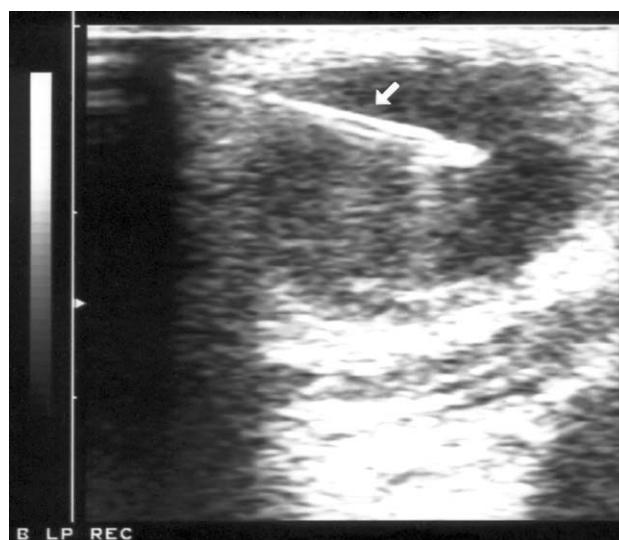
Ultrasonographic view of the needle in the center of the parotid mass.
